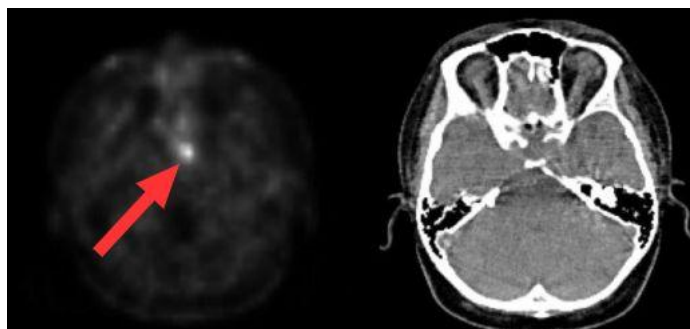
Pituitary imaging (PET CT - left image, CT - right image) with the possible location of the tumor pointed by the red arrow
